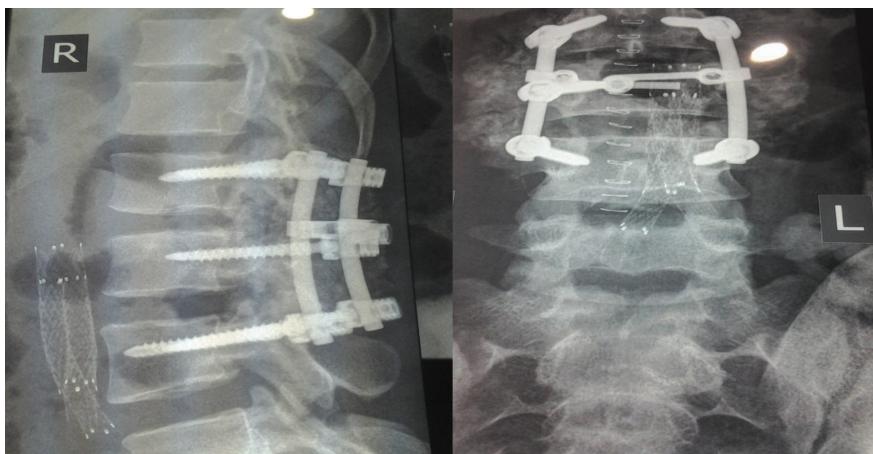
Plain X-ray showing stents in aorta and iliac arteries at 8 months follow-up.
